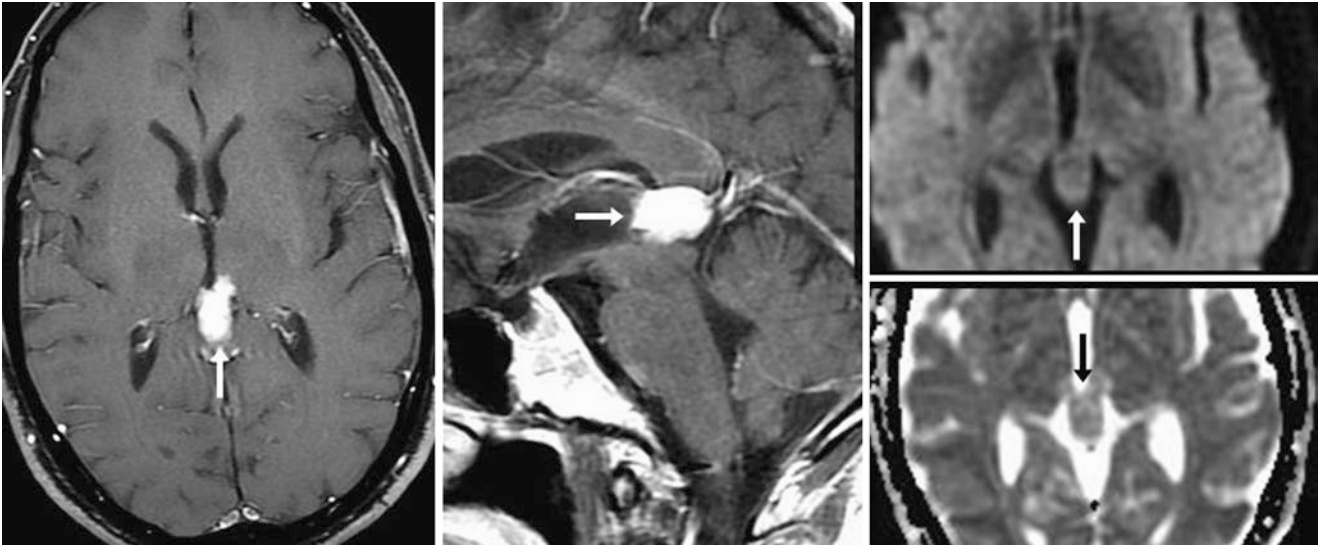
Comparison case of pineal region meningioma (benign): a 52-year-old patient with a 20-mm pineal mass (*arrows*) on postcontrast axial (*left*) and sagittal (*middle*) T1WIs. The mass did not have reduced diffusivity on DWI (*right, top image*) or on ADC map (*right, bottom image*). A dural tail (which is typical of meningioma) was not visualized
